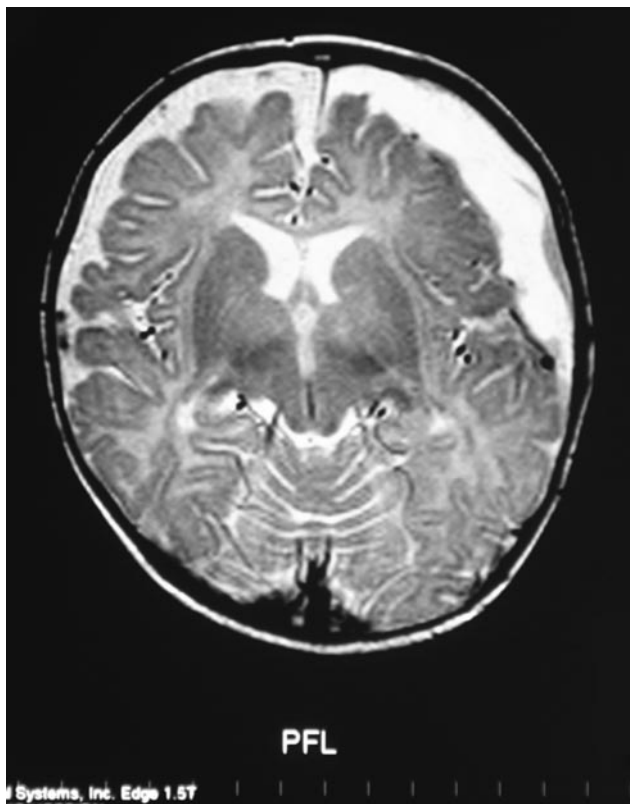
Contrast-enhanced head magnetic resonance imaging scan, showing evidence of bilateral subdural collections with left-sided predominance and mild midline deviation. No brain or epidural abscesses were found.
